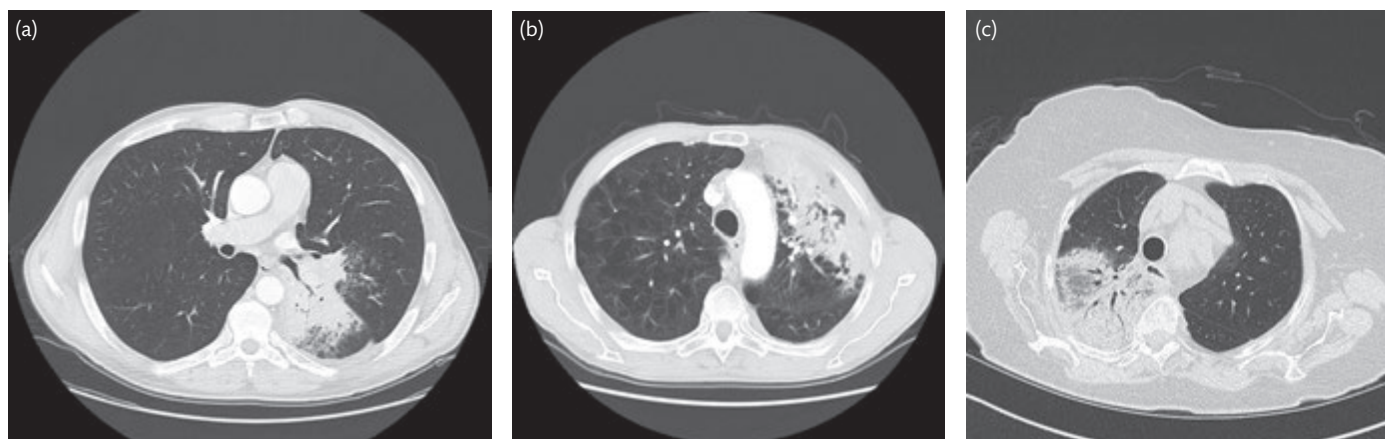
CT appearances of (a) cryptogenic organizing pneumonia, (b) lung adenocarcinoma, (c) lobar pneumonia.
